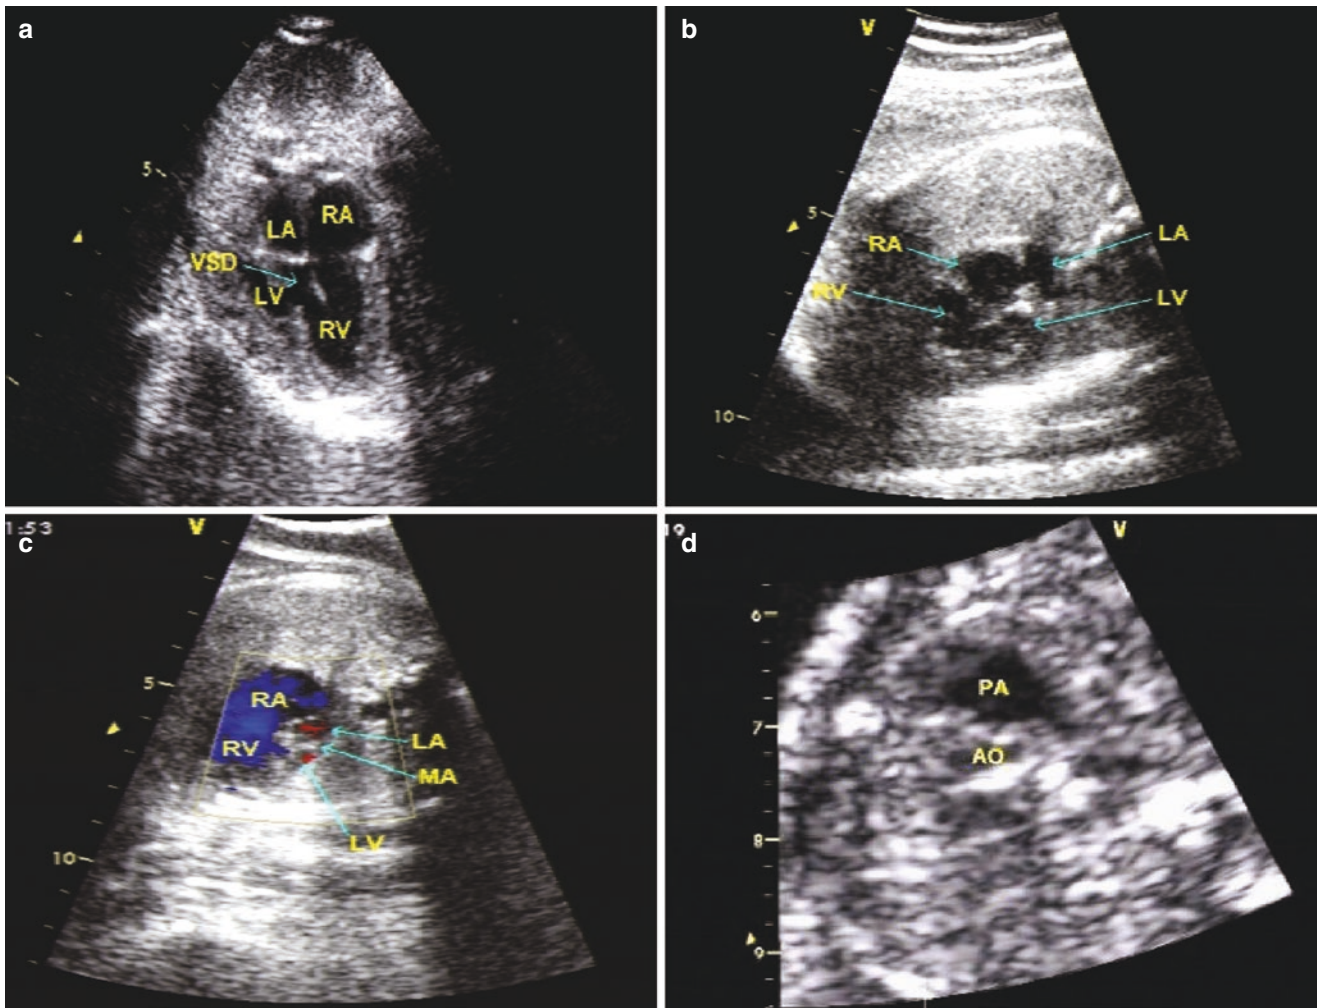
Hypoplastic left heart syndrome. (a) Fetal mitral atresia: mitral valve did not open during diastole; small LA and LV; (b) The structural abnormality is the same as Fig. 4.14a. (c) Color Doppler flow
